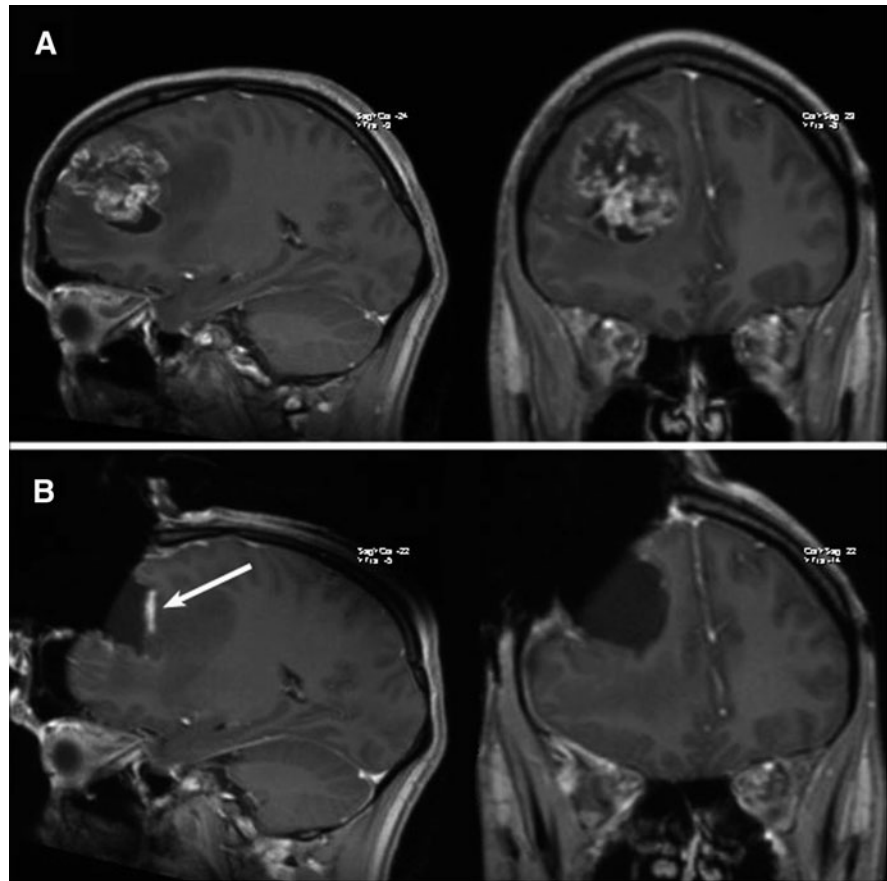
(a) Preoperative coronal T1-weighted MRI with contrast enhancement of a patient harbouring a right frontoparietal glioblastoma. (b) First intraoperative control showing a contrast-enhancing tumor remnant adjacent to the resection cavity
